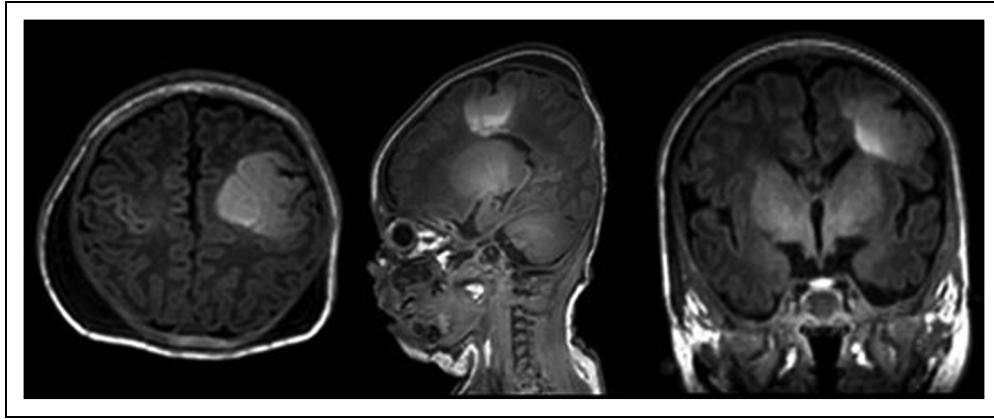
MRI obtained on day of life 4 demonstrated T1 hyperintensity in the left posterior frontal lobe associated with abnormal gyration pattern that may reflect an area of cortical dysplasia.
